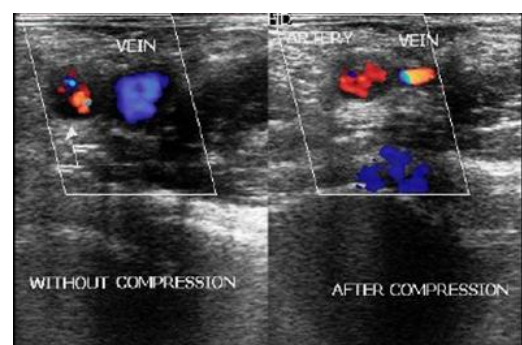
At each level, the first step is to search for vein, perform compression study at every few centimetres and evaluate the spontaneous flow signals by colour Doppler.
